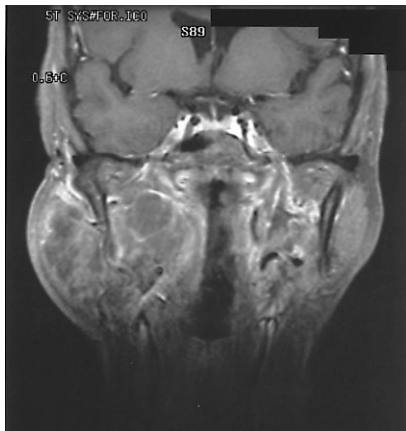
A 54-year-old female who had lymphangioma with no evidence of malignancy on pathological report. This coronal contrast-enhanced, fat-suppression MR image through the parotids shows a heterogeneously enhanced large mass in the right neck (*left*). Coronal ^{67}Ga SPECT reveals little or no uptake by the lesion (*right*). Confidence in the diagnosis of malignancy by two of the three readers was improved by adding ^{67}Ga SPECT (possibly benign to probably benign, probably malignant to possibly benign).
